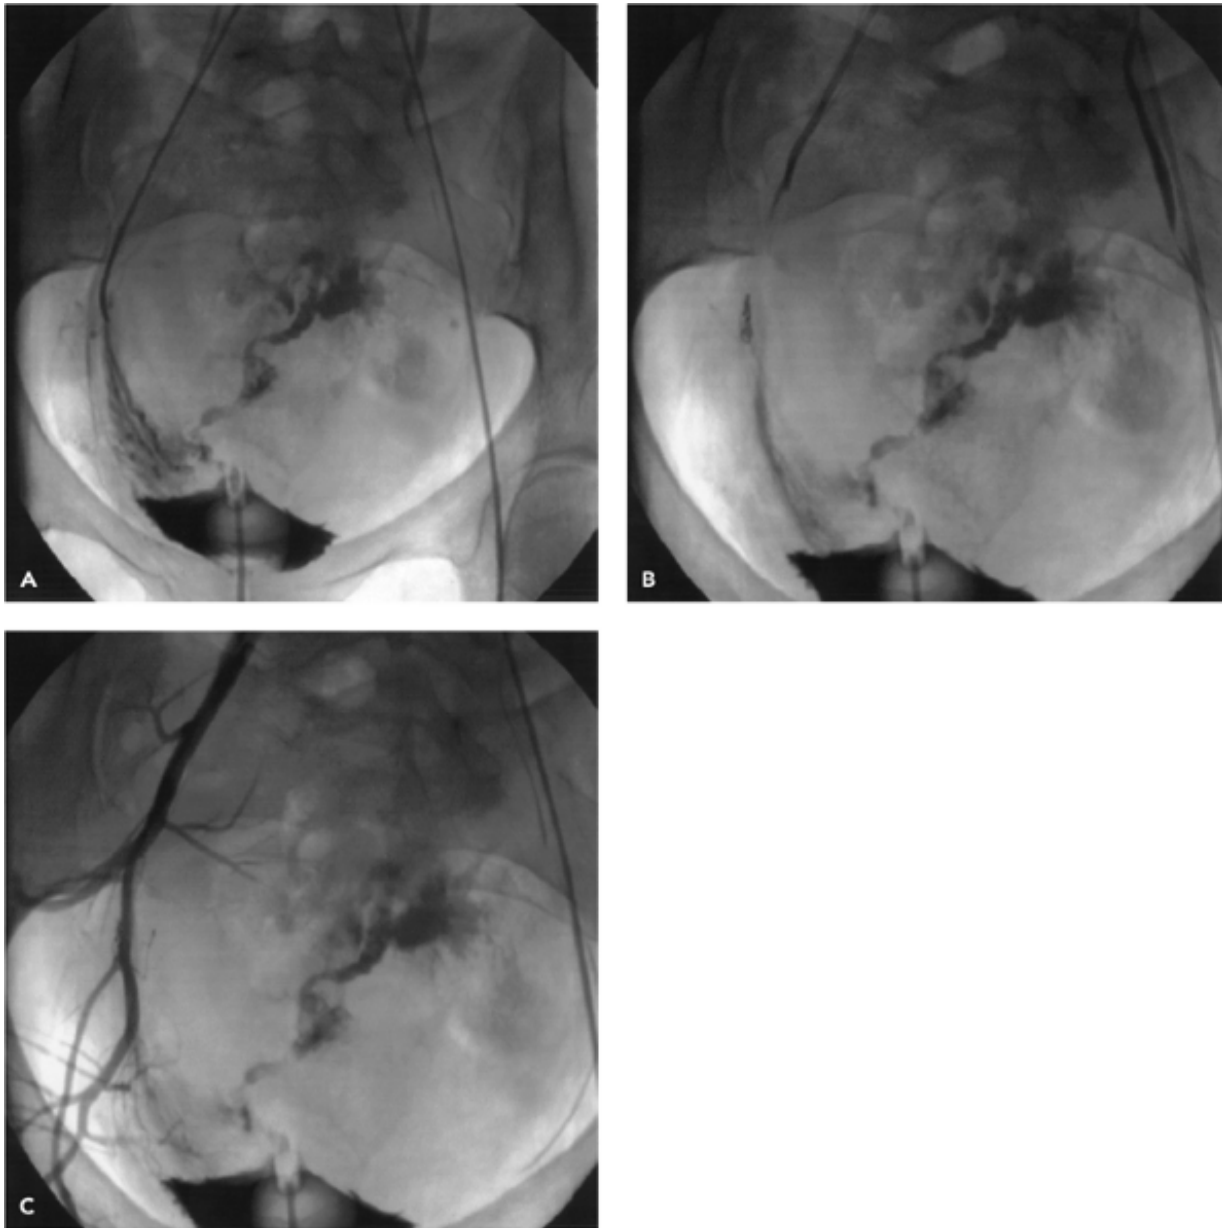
A: A young woman who is postoperative hysterectomy had a falling hematocrit, and CT scan demonstrated blood pooling in the pelvis and abdomen. A catheter has been inserted in the left femoral artery and threaded around to the right hypogastric. Injection of contrast shows extravasation in the pelvis. B: A small coil is used to embolize the bleeding vessels. C: Reinjection of contrast shows no further extravasation. There is residual contrast in the pelvis (compare with figure 31.1A). (Courtesy of Leann S. Stokes, M.D., Department of Radiology, Vanderbilt University.)
